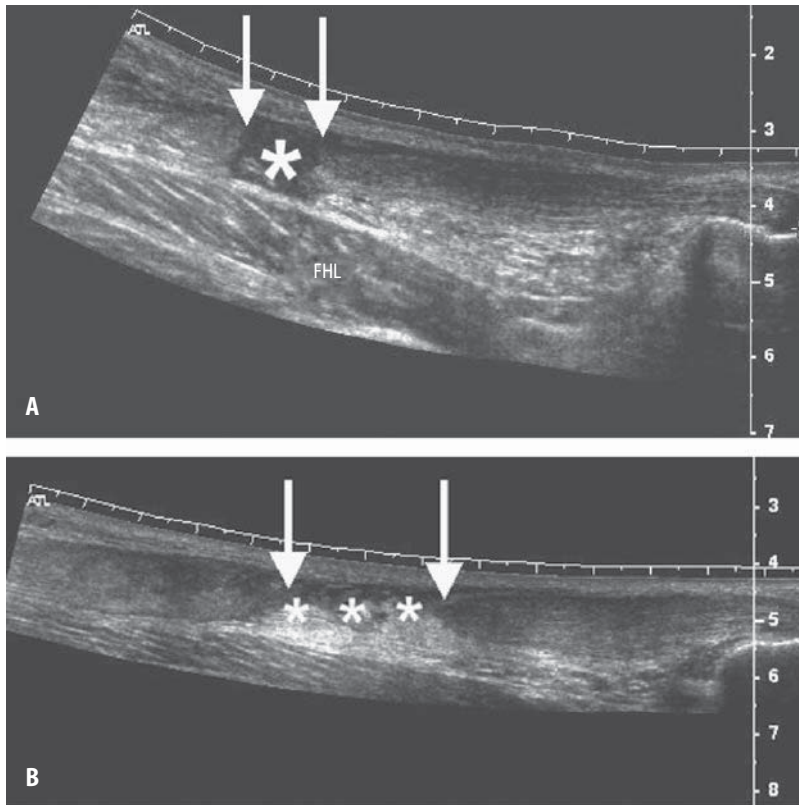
(A) Longitudinal extended field of view ultrasonographic image of a complete tendon tear showing the gap in the tendon (*) and the torn tendon ends (solid arrows). The muscle belly of flexor hallucis longus is well seen deep to the tear.
